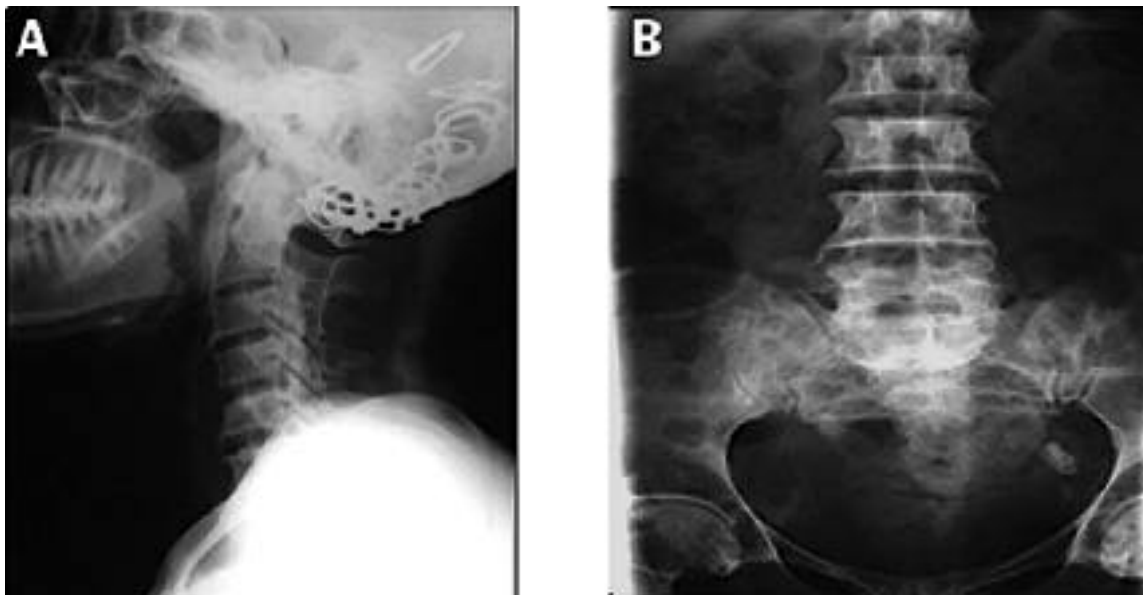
Plain x-rays of the cervical and lumbosacral spines. (A) Cervical spine lateral view. New bone is seen inferiorly at the level of C1-2 and posteriorly in the canal in the line of the posterior longitudinal ligament. (B) Lumbosacral spine antero-posterior view showing ossification of the sacrospinous ligament.
